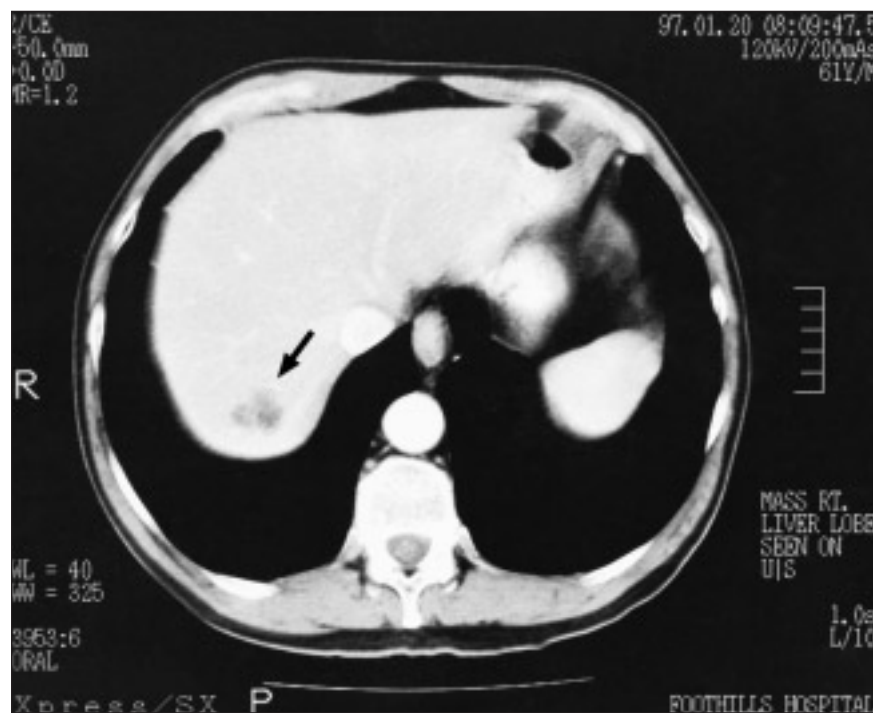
Case 1: CT scan showing a cystadenoma (arrow) 3-cm in dimension located in hepatic segment VII. Internal septations are visible.
